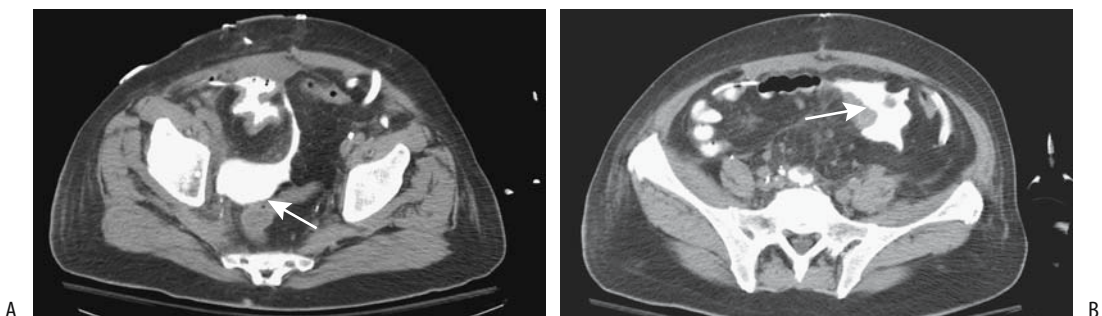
Bladder leak after subtotal cystectomy and neobladder formation. A: CT cystogram identifies contrast in the bladder and extravasation posteriorly (arrow). B: Extravasation also extends to the left, adjacent to bowel (arrow). (Source: Titton R, Gervais DA, Hahn PF, Harisinghani MG, Arellano RS, Mueller PR. Urine leaks and urinomas: diagnosis and imaging-guided intervention. *RadioGraphics* 2003;23:1133–1147, with permission from the Radiological Society of North America.)
